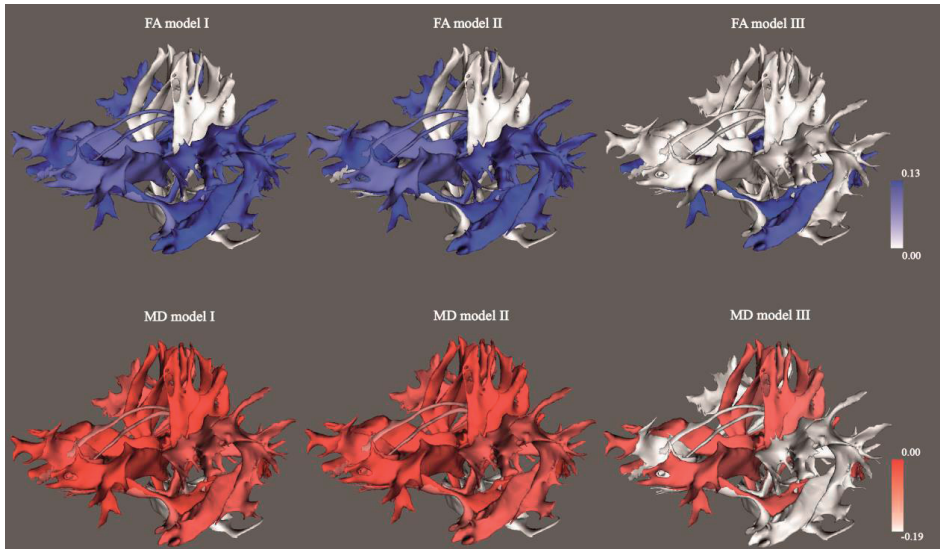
Diffusion-MRI measures and global cognition
